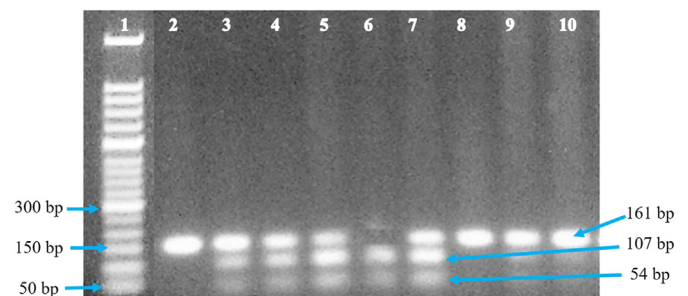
Restriction endonuclease (*XbaI*) digestion fragments of *HHEX* rs1111875 polymorphism (2% agarose gel). Lane-1: 50 bp molecular marker; Lanes- 3, 4, 5 and 7: heterozygous (CT) form (54, 107 and 161 bp), Lane- 6: homozygous (TT) form (54, 107 bp), and Lanes- 2, 8, 9, and 10: wild-type (CC) form (161 bp).
